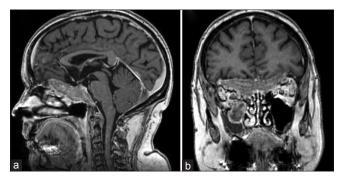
T1-magnetic resonance imaging ([a], sagittal, [b], coronal) showing the consistent lesion volume reduction after steroid treatment
